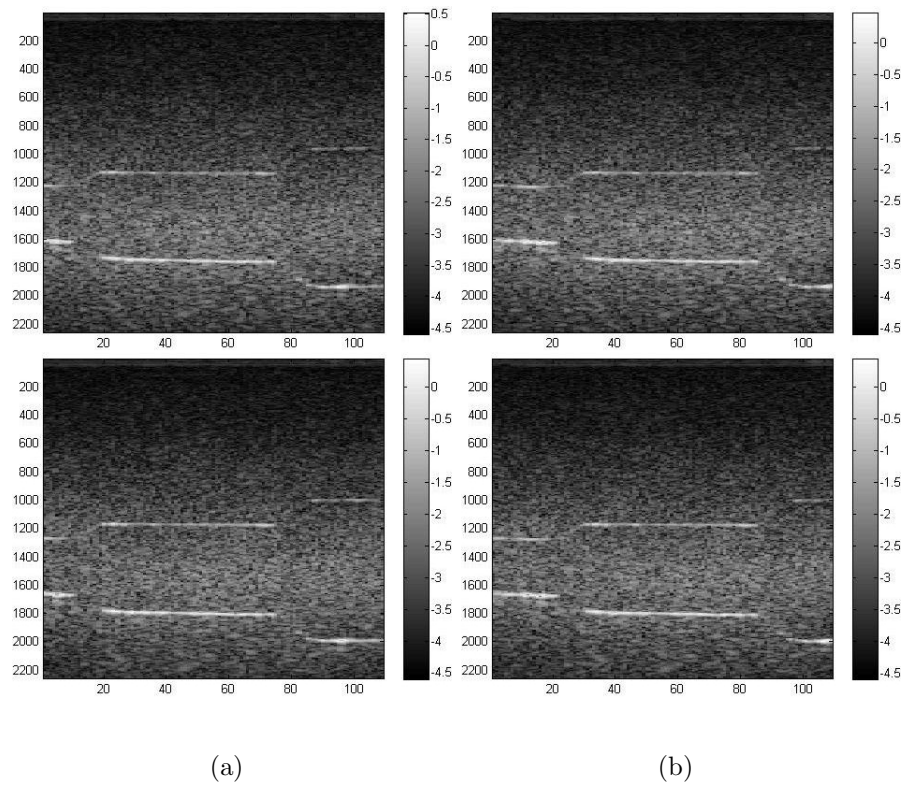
Bmode ultrasound data before and after compression for (a) position t_0 , and (b) position t_1 .
